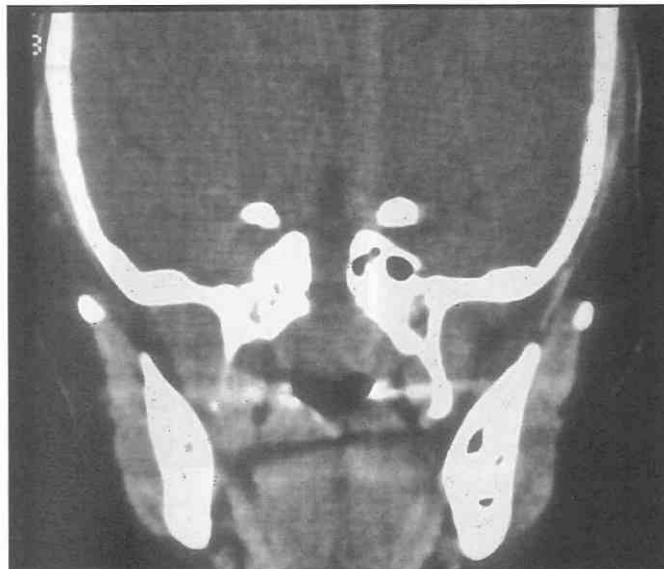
Basal cephalocele. Coronal nonenhanced CT scan shows a large midline, isodense nasopharyngeal soft tissue mass that is significantly compromising the airway in a child. The obvious associated midline skull base defect represents the persistent hypophyseal (craniopharyngeal) canal and suggests that the postnasal mass is actually a herniated pituitary gland. Note the consequent downward traction of the suprasellar cistern into the basal defect.
